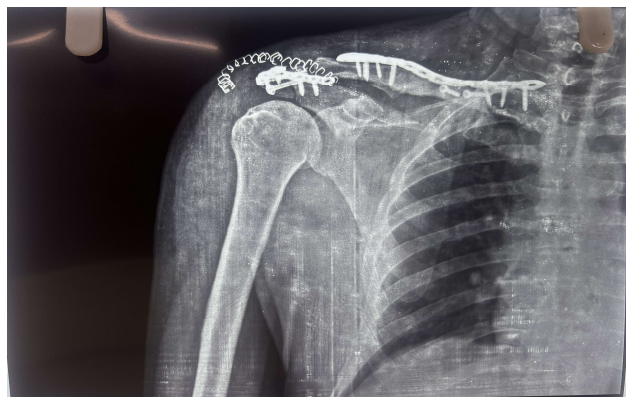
Post operative xray with MESH Plate
